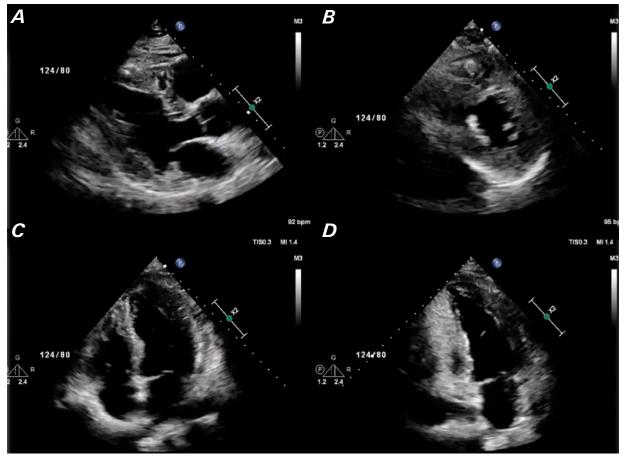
Transthoracic echocardiograms in A) parasternal long-axis, B) parasternal short-axis, C) apical 4-chamber, and D) apical 5-chamber views show mild left ventricular hypertrophy and a normal left ventricular ejection fraction. The accompanying motion image shows lateral wall tethering.
